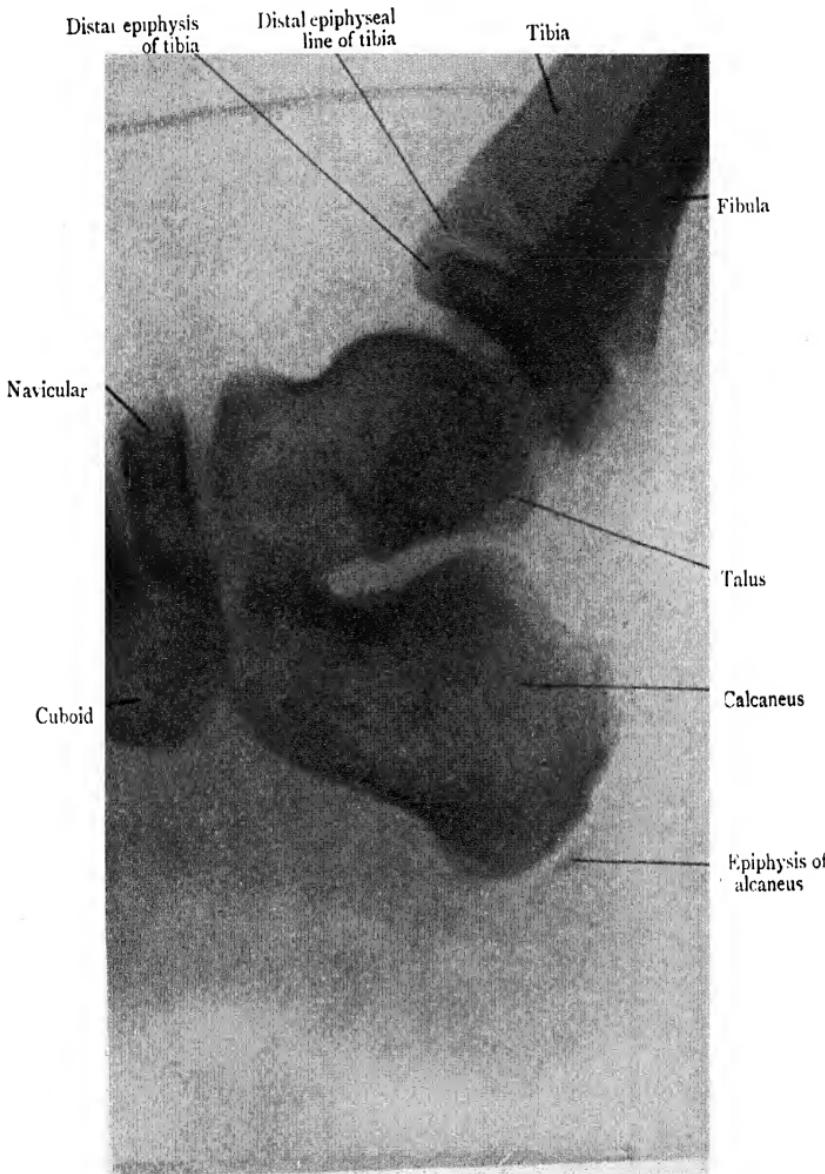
Radiograph of the Foot of a Child 6 years old.
